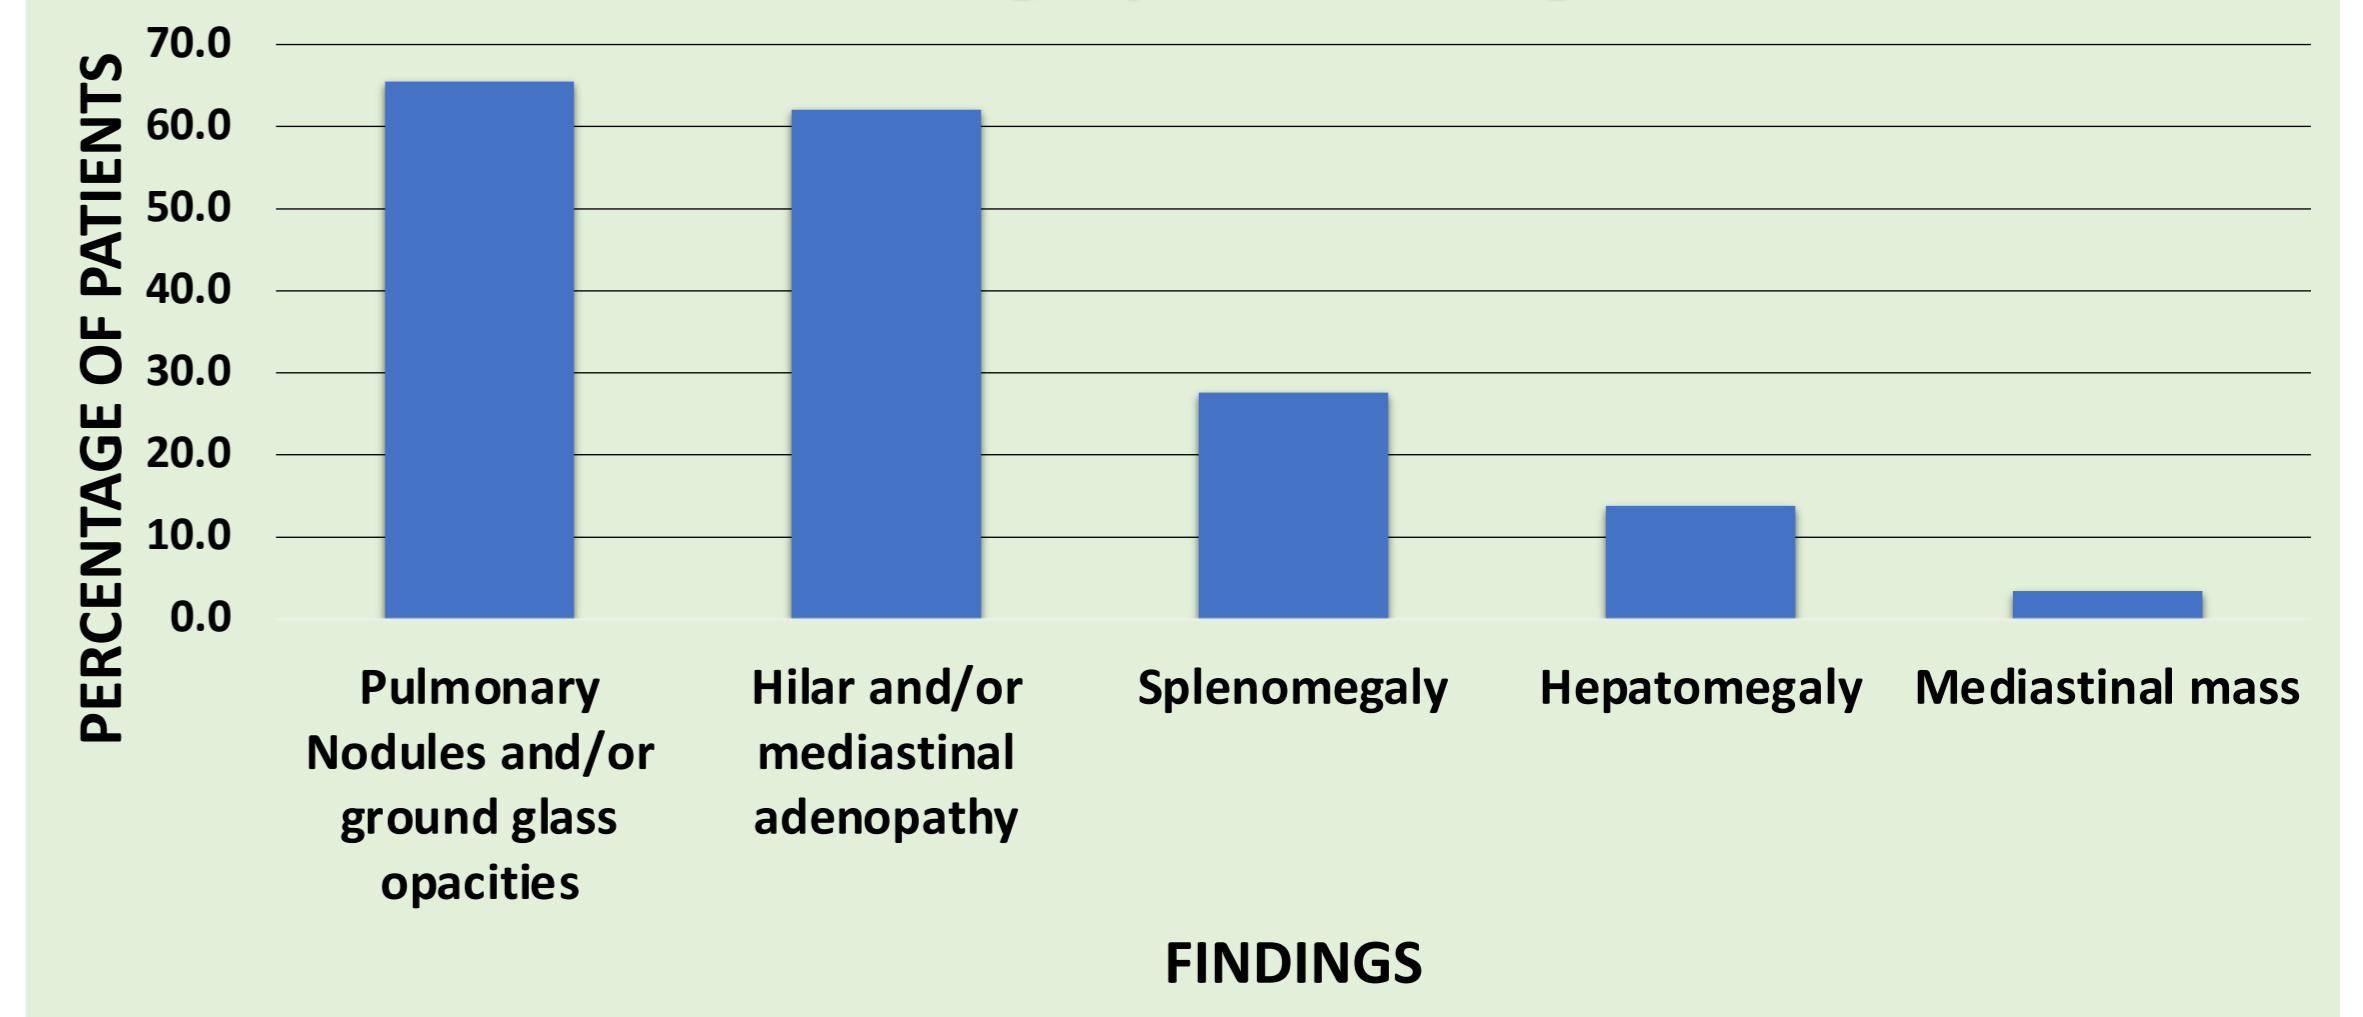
Common radiographic manifestations in histoplasmosis: Pulmonary nodules/ground glass opacities was the most common radiographic finding, most of whom had hilar/mediastinal lymphadenopathy as well.
